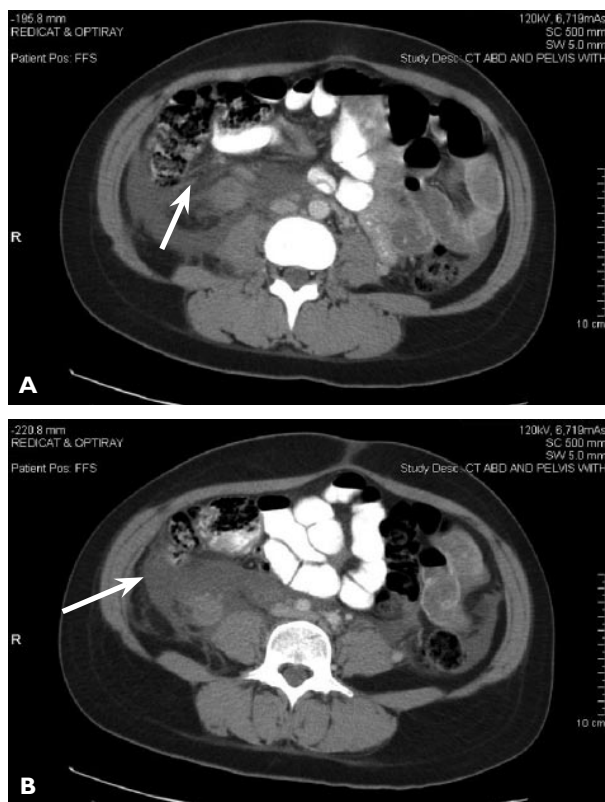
Abdominal computed tomography scan of patient 1 demonstrating (A) retroperitoneal hematoma (arrow) and (B) ovarian vein thrombus (arrow).
